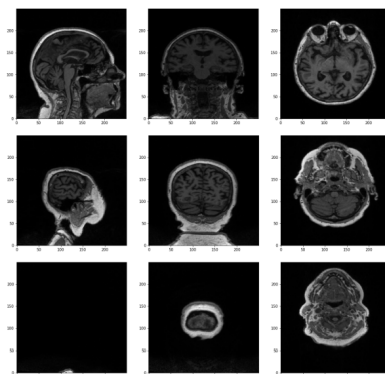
Examples of MRI slices as distance increases from center
